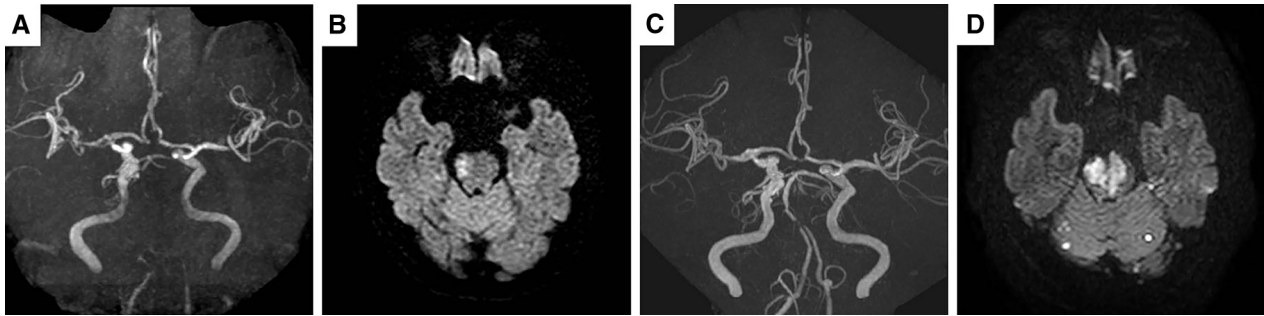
(A) MRA at onset: Bilateral vertebral arteries over the trunk of the basilar artery were not visualized. The basilar artery tip was visualized through the right posterior communicating artery. (B) Diffusion-weighted MRI at onset: A high-intensity area was present on the right side of the midbrain. (C) MRA on the day following onset after
